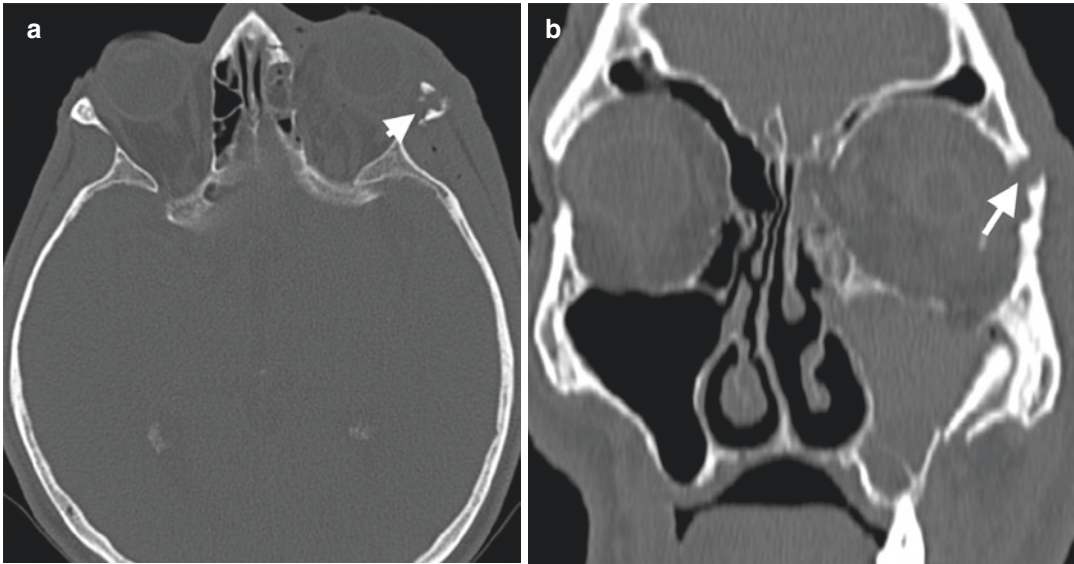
Lateral wall fracture of the orbita. Axial (a) and coronal (b) CT images of a 52-year-old male patient with MVA show lateral wall fracture (arrows) of left orbita
